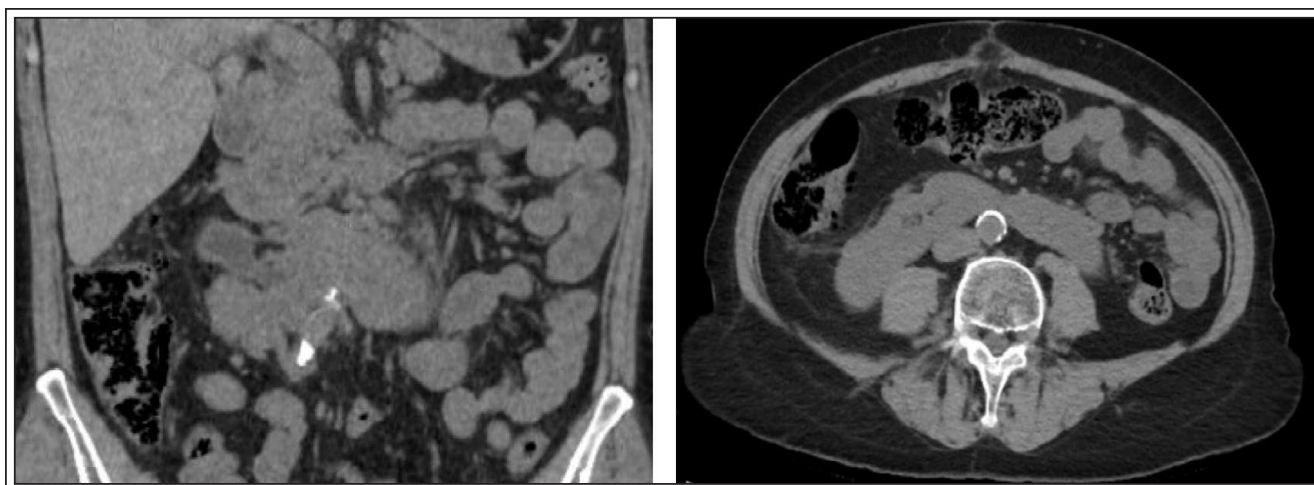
Preoperative computed tomography scan of a horseshoe kidney with a stone burden in the right renal pelvis (coronal and axial views). Note almost retrorenal colon precluding safe percutaneous access.
